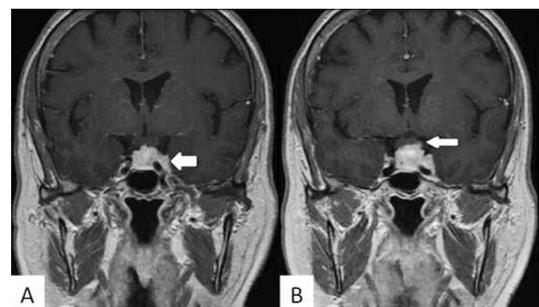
Left cavernous sinus invasion (A, arrow) and compression of the optic chiasm (B, arrow) were observed on contrast-enhanced T1-weighted coronal images.
